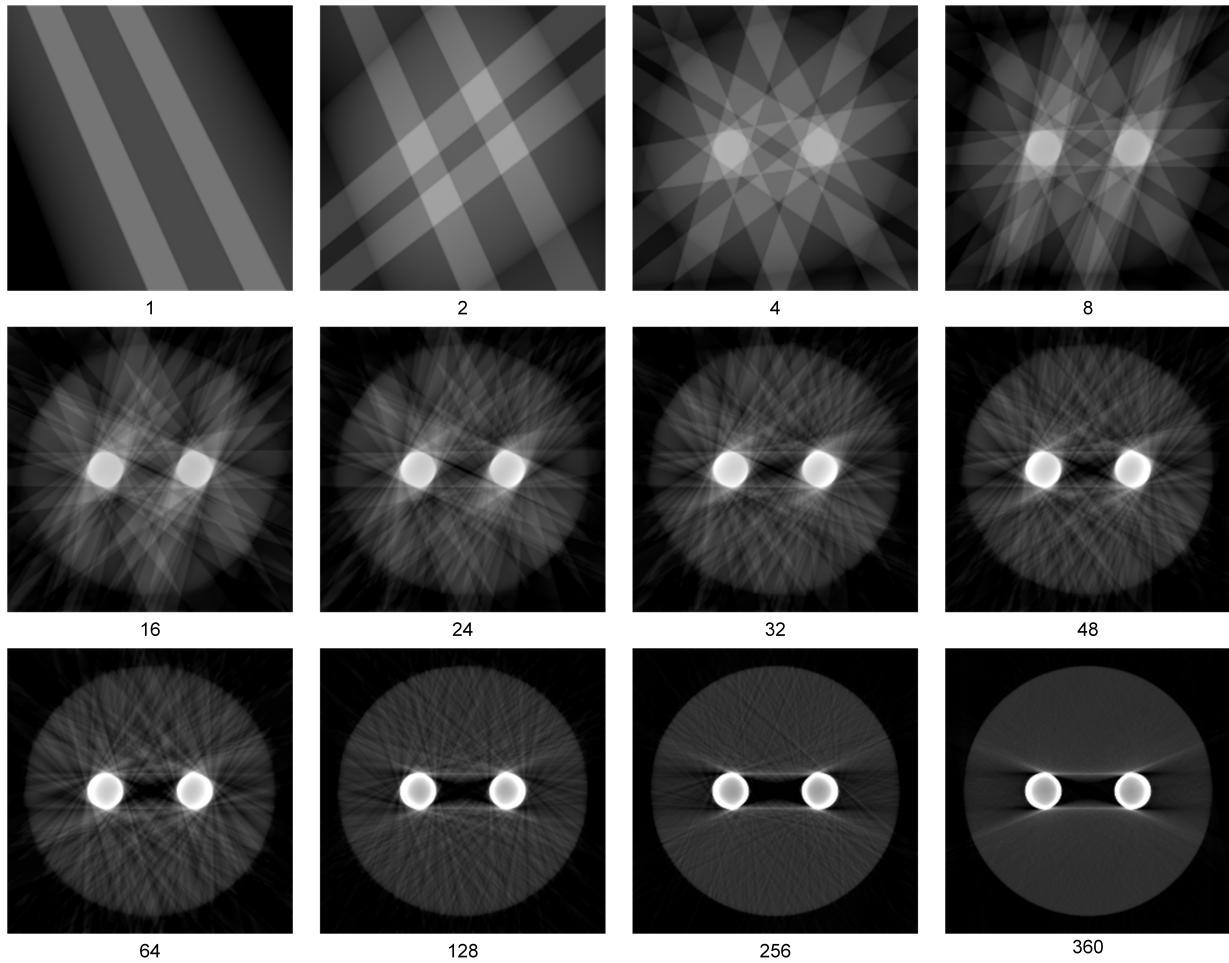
An example showing the evolution of metal artifacts in a representative CT slice during the reconstruction of a CT volume by applying the SART algorithm.
